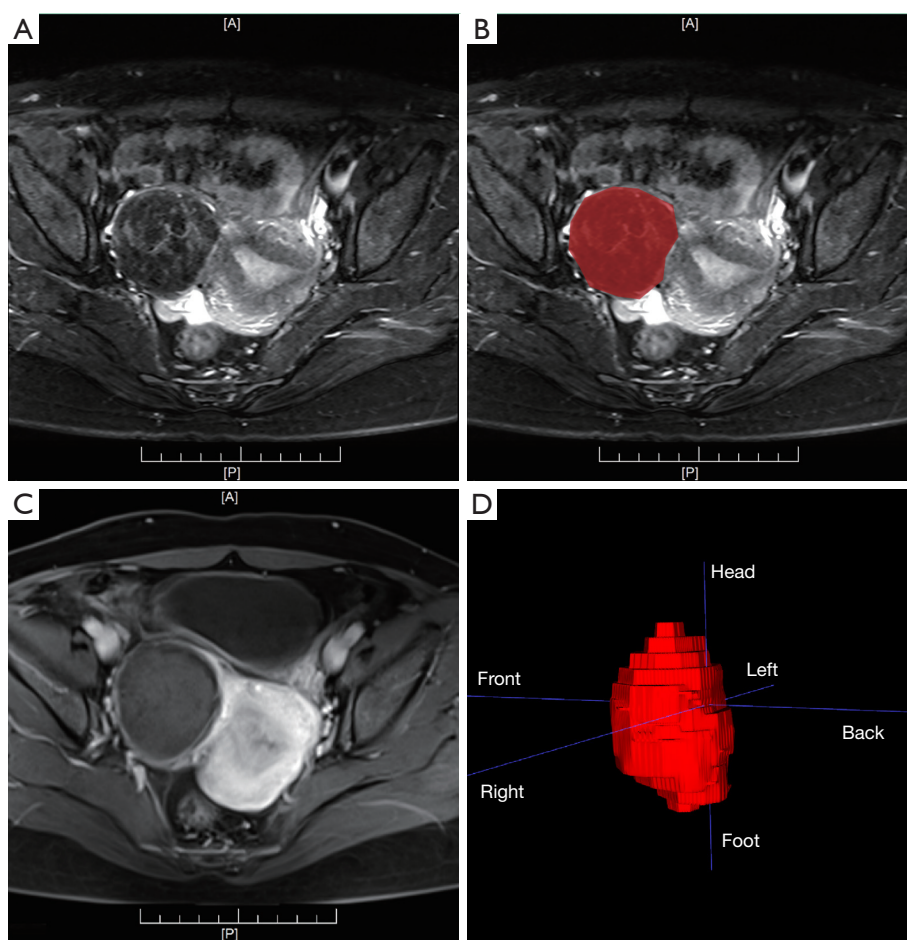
ROI extraction of uterine fibroids using the ITK-SNAP software. (A) A subserosal fibroid with low intense signal on the right lateral wall of uterus in T2WI; (B) the red part shows the mask of the fibroid delineated manually in T2WI; (C) the NPVR reached 100% in contrast-enhanced T1-weighted imaging; (D) 3D visualization of fibroid in ITK-SNAP. The minimum scale in these pictures is 10 mm. ITK-SNAP is a free, open-source, multi-platform software application from <http://www.itksnap.org/pmwiki/pmwiki.php>. ROI, region of interest; T2WI, T2-weighted imaging; NPVR, non-perfused volume ratio; 3D, three-dimensional.
